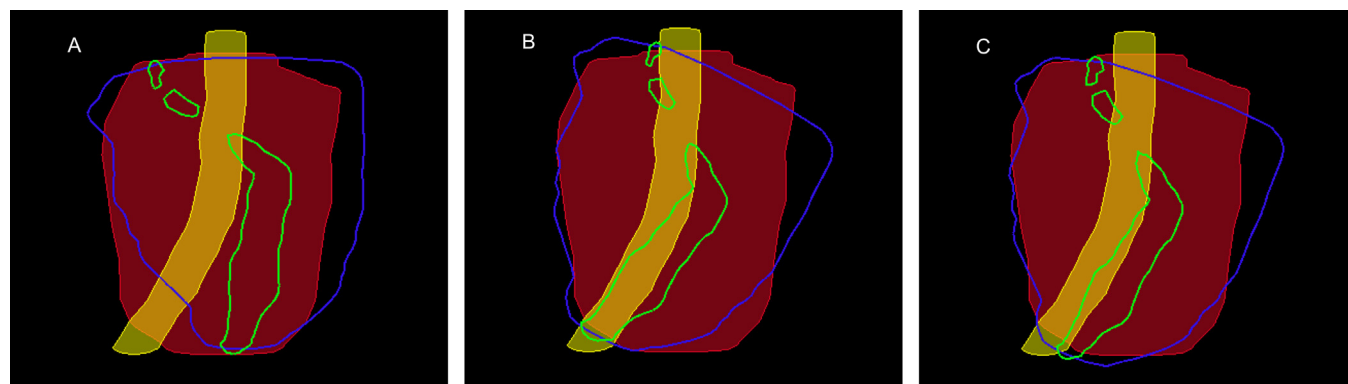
Representation of A) centered, B) autoaligned, and C) manual initialization points for a sample case. Filled slices are from TRUS segmentation and contours from MRI segmentation: prostate (red and blue) and urethra (yellow and green). (For interpretation of the references to colour in this figure legend, the reader is referred to the web version of this article.)
